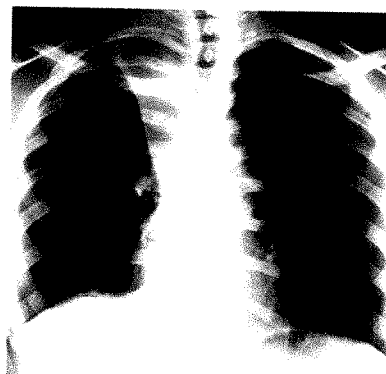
Chest radiograph shows atelectasis of right upper lobe of lung and left hilar adenopathy.
